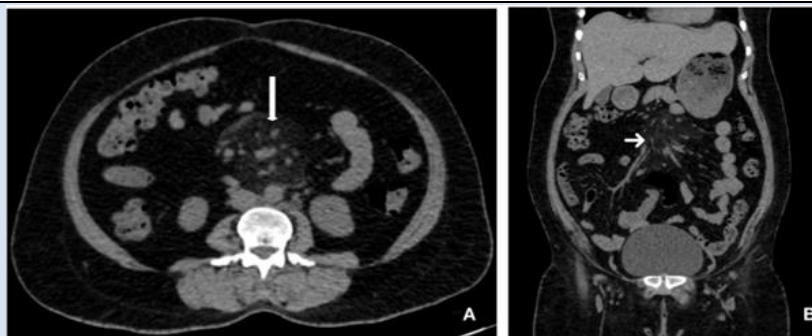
(A and B) Encapsulated fat necrosis in a 45-year-old female patient who underwent hysterectomy for fibroid uterus 15 days back. CT abdomen plain axial (14A) and Sagittal (14B) images show well defined encapsulated area of fat necrosis in the right Para median location in the infraumbilical region.
